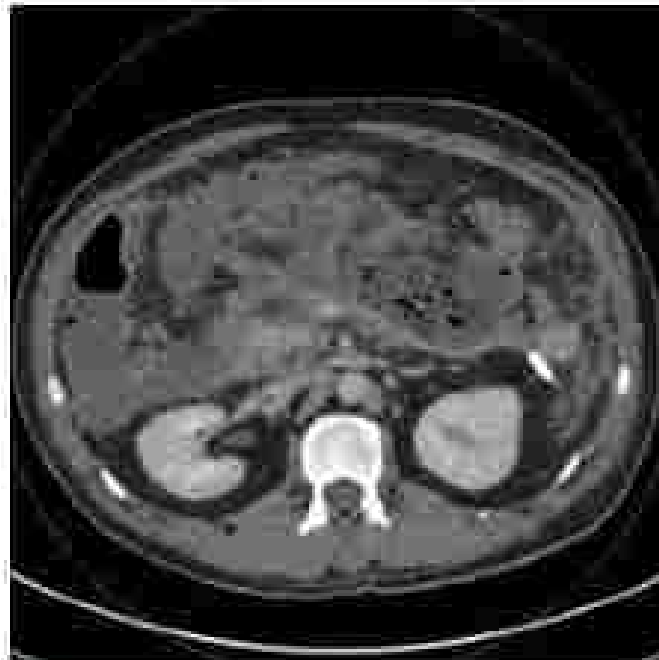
Computed tomographic image showing peripancreatic drain crossing the left flank into a nonperitoneal collection.
